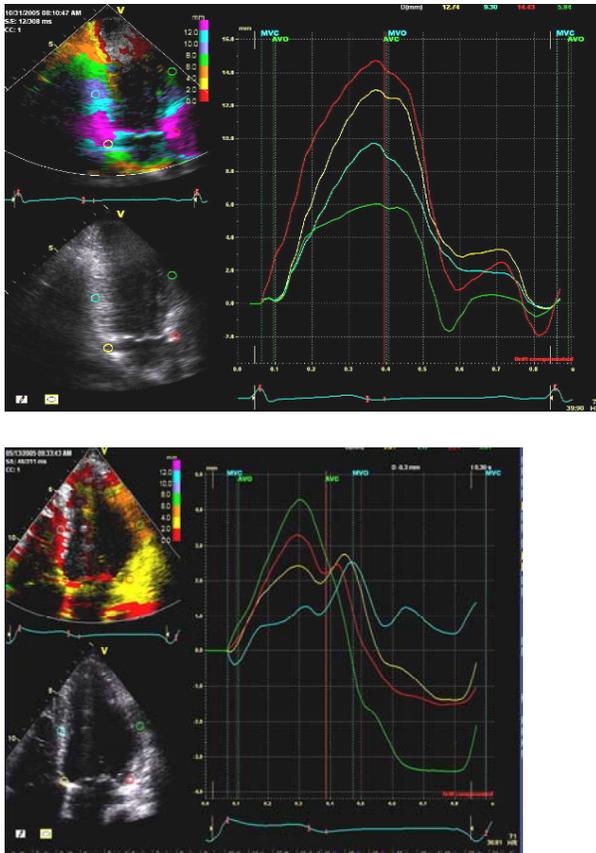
Apical 4-chamber tissue tracking curves of a normal (left panel) and dyssynchronous (right panel) heart. In the normal heart, all wall segments reach peak displacement at the same time, at aortic valve closure. In the dyssynchronous heart, wall segments do not reach peak displacement at the same time, and may reach a peak after aortic valve closure.
